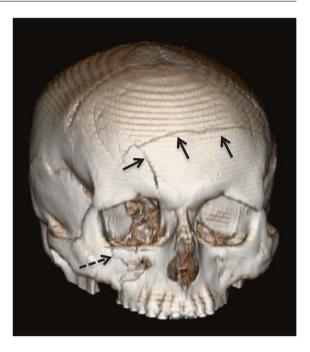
A 3D reconstruction of a CT performed for a patient with a comminuted frontal bone fracture (solid arrows). There is also a fracture of the right maxilla (dashed arrow)
